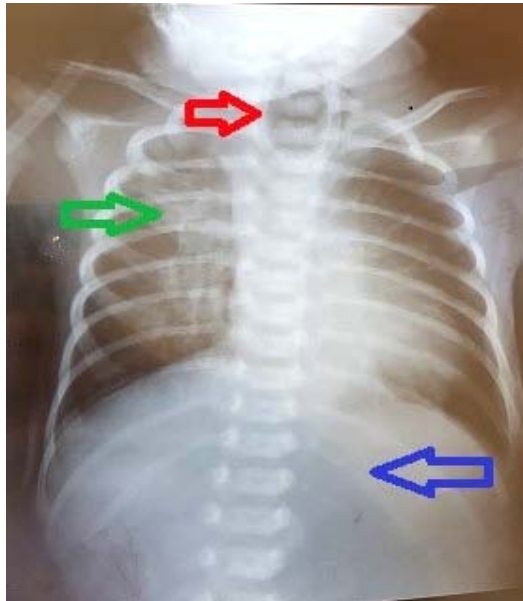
A frontal chest and abdominal X-ray showing the NG tube coiled in the upper pouch at T3 level (red arrow) with the absence of air in gastrointestinal tract (blue arrow). We notice the presence of interstitial syndrome in the right middle and superior lobe in favor of a pneumopathy (green arrow).
